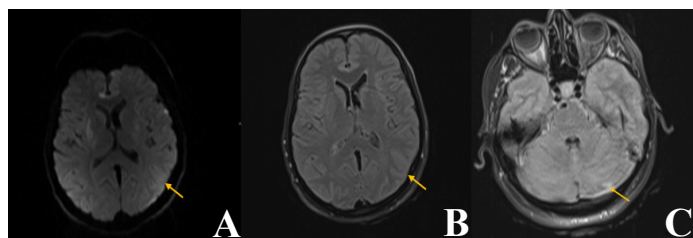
Leukoencephalopathic oedema seen on FLAIR (1B) and diffusion (1A) weighted sequences extending from bilateral peripheral cerebellar regions to posterior parieto-occipital juxtacortical areas. Left cerebellar lesion (1C)
